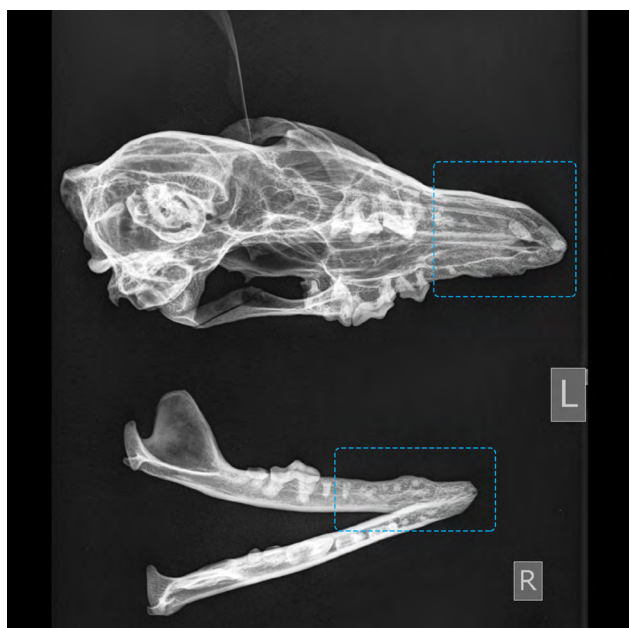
X-ray of skull and mandible in Fig. 5 and Fig. 6: alveoli with roots or total disappearance, vertical bone resorption and acute porous bone tissue (marked by squares) in a female red fox.
